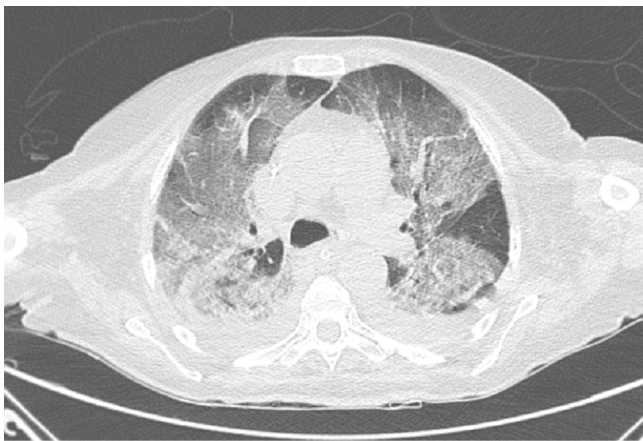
Chest CT of case 2.
